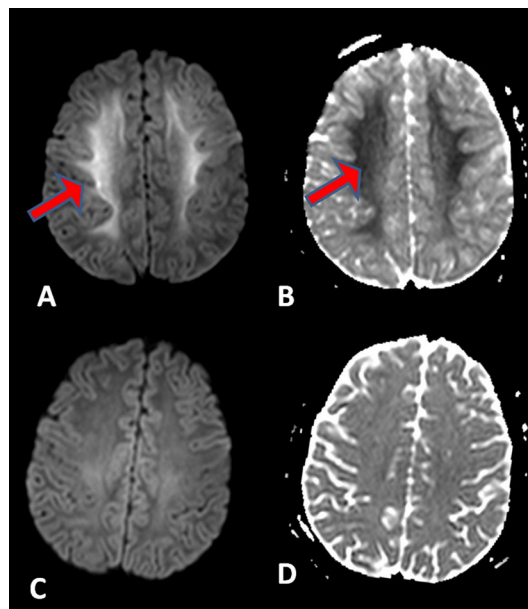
(A) Diffusion-weighted MRI showing restricted diffusion (hyperintensity pointed by red arrow) with (B) showing corresponding hypointensity on apparent diffusion coefficient map. (C) and (D) show the reversal of the changes in (A) and (B), respectively.
